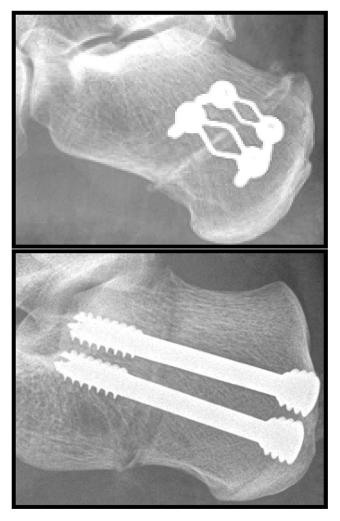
Example of 2 de-identified patient cases consisting of a clear lateral radiograph.
